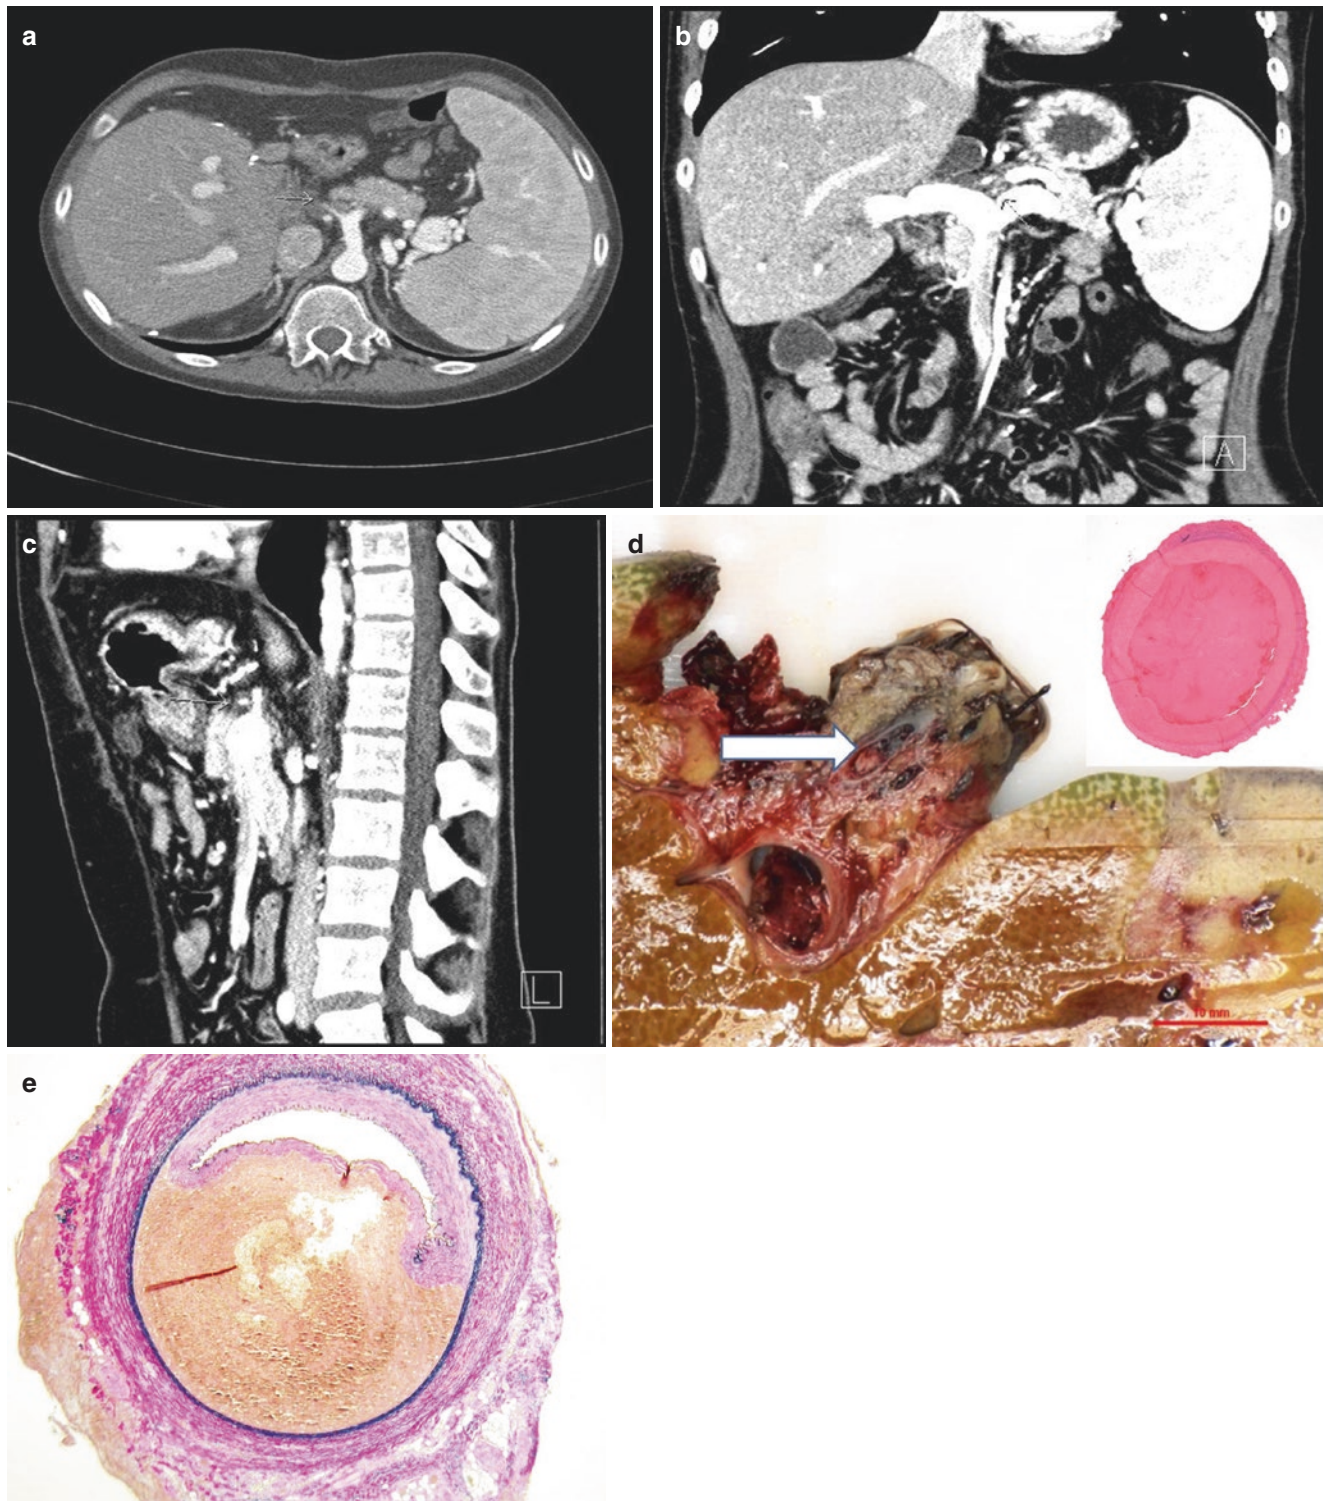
(a–c) Intravenous contrast enhanced CT scan of the abdomen reveals narrowing of the hepatic artery at its origin from coeliac axis with complete occlusion distally. (d) This gross image from an
